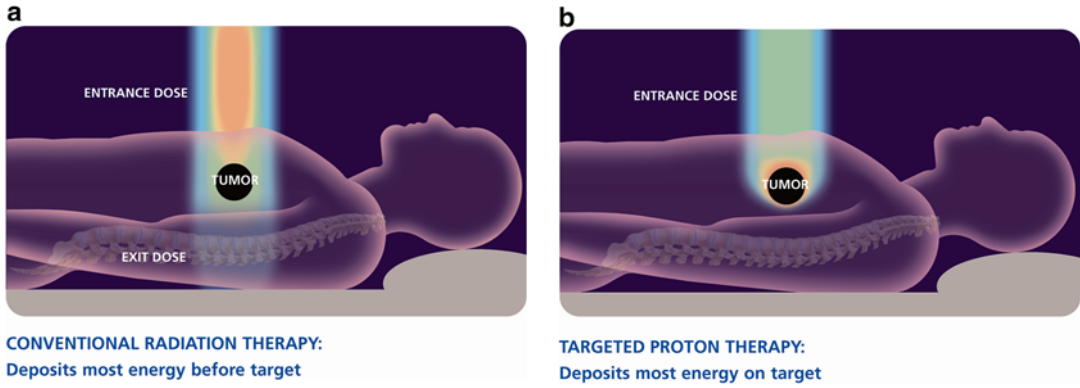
With conventional radiotherapy (a) using X-rays (photons), the highest dose is near the point of beam entry into the patient. The tumor dose is significantly less than the entry dose. Also, an exit dose is delivered beyond the tumor target. With protons (b) and other
